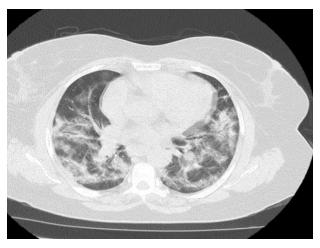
Computed tomographic (CT) scan of the chest confirming the bilateral subpleural Ground Glass Opacifications and septal thickening consistent with COVID-19 pneumonia.
